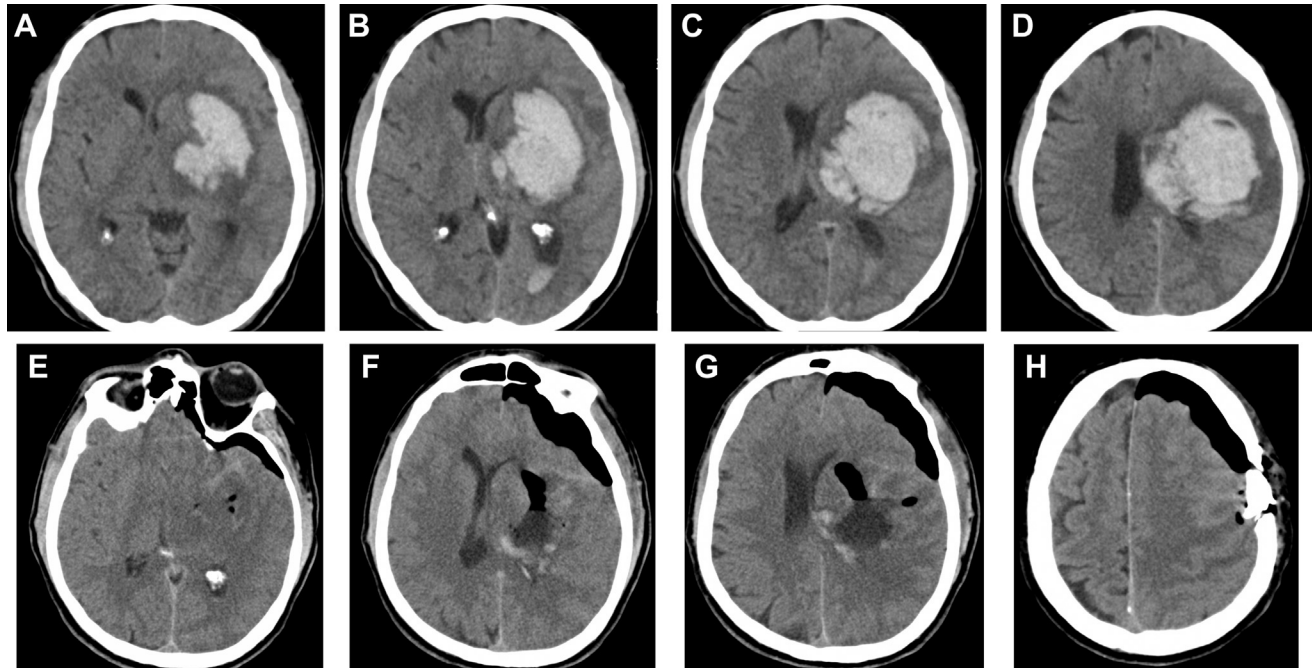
(A–D) Preoperative computed tomography scan showing a large deep supratentorial intracerebral hemorrhage (72 mL) with significant midline shift. (E–H) Postoperative computed tomography scan showing near-total clot evacuation (residual clot volume 4 mL) and midline shift reduction.
